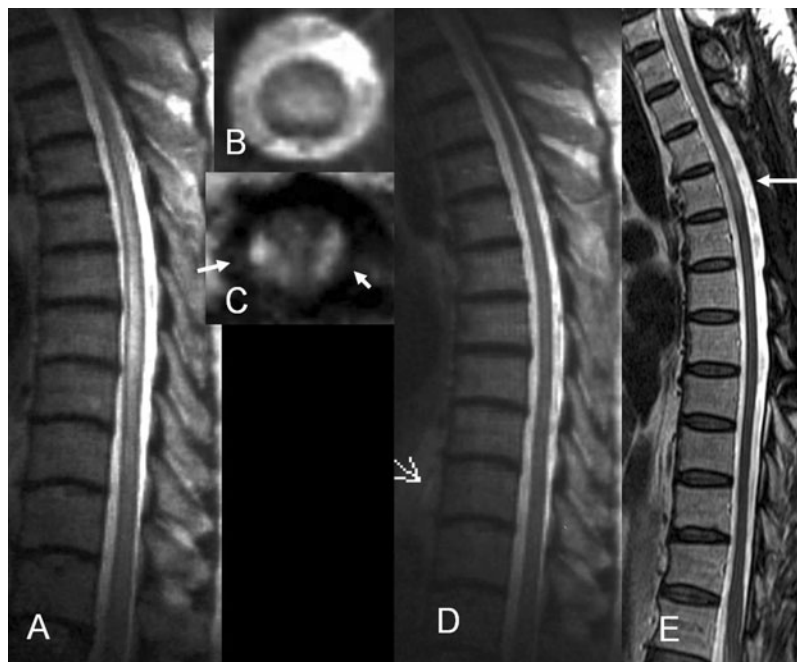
MRI from patients 10 and 11. Patient 10 (A–D): Sagittal T2WI revealed a high-intensity lesion at the middle thoracic cord levels with spinal cord swelling (A). Axial T2WI showed high intensity lesions at the center of spinal cord (B), and Gd-enhanced axial T1WI revealed focal enhancement in lateral columns on both sides (C). High-intensity lesions at the thoracic cord levels disappeared 1 year later (D). Patient 11 (E): Sagittal T2WI revealed a high-intensity lesion at the upper thoracic cord level (*arrow*).
